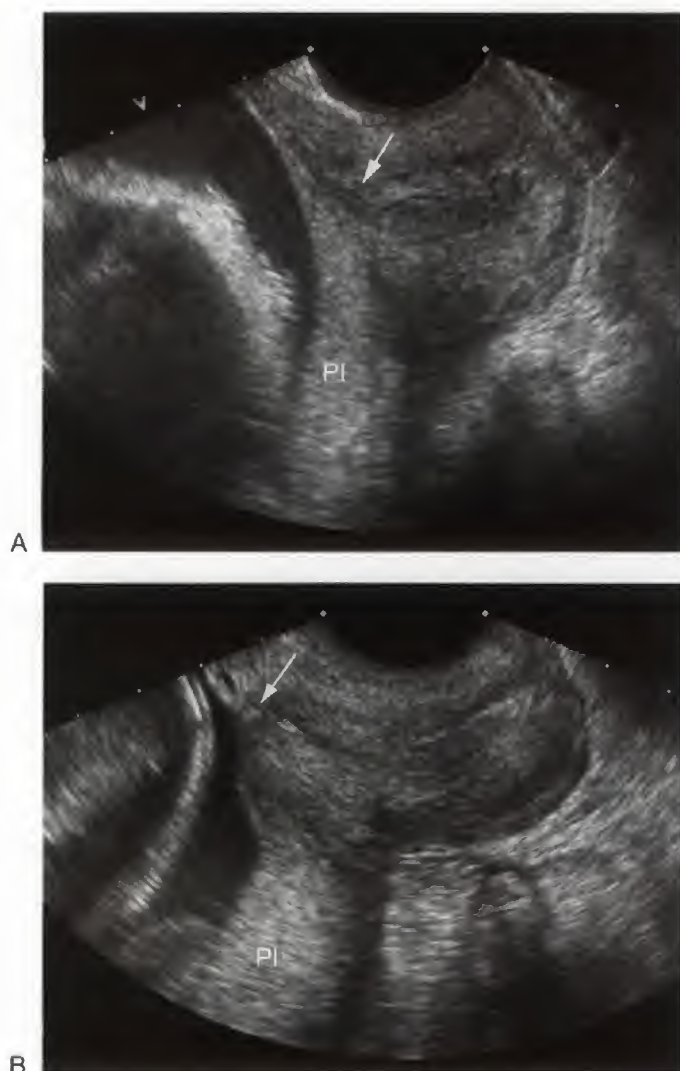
A and B. Two examples of complete central placenta previa shown by transabdominal ultrasound in the late second trimester. Placental tissue completely overlies the cervix. Pl, placenta. Cervix (arrow).
